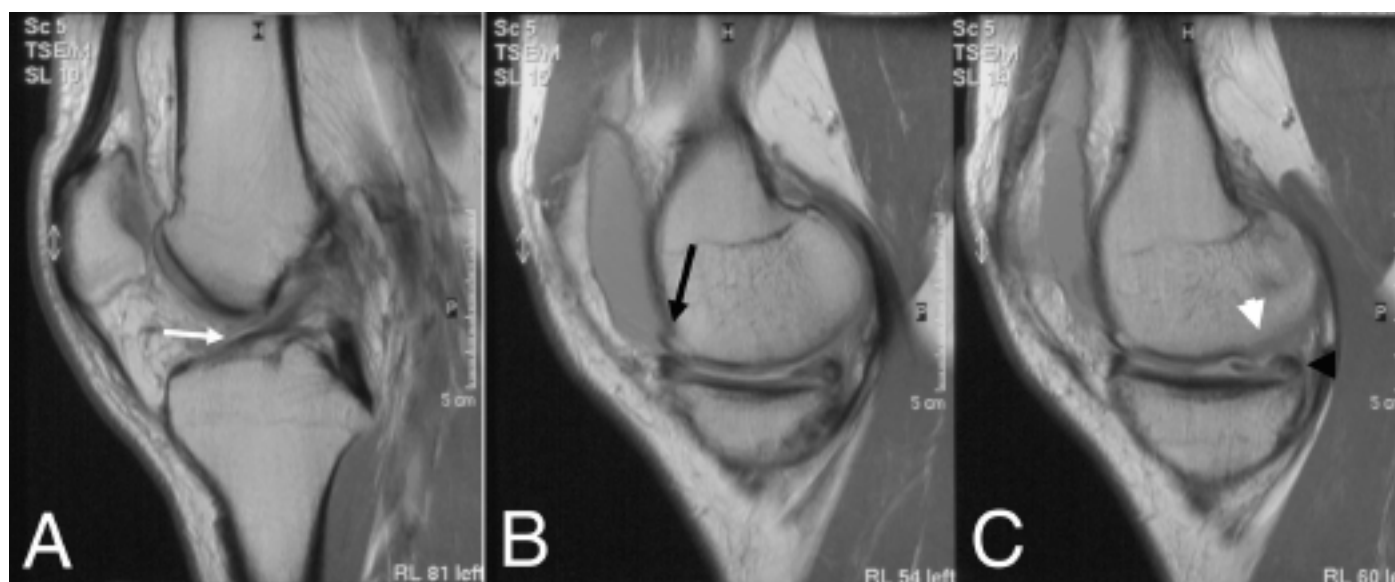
This sagittal T1 weighted MRI scan shows degenerative changes present in the medial compartment of the knee in a male subject with 12-year history of chronic ACL-deficiency. In the left image (A) can be seen a chronic ACL tear with attrition of remaining strands (white arrow), in the centre (B) and right images (C), medial compartment degenerative changes including osteophytes (black arrow), chronic tear of the posterior horn of the medial meniscus (black arrowhead), and damage to the articular surface of the femoral condyle (white arrowhead). There is also an effusion medial to the patella.
